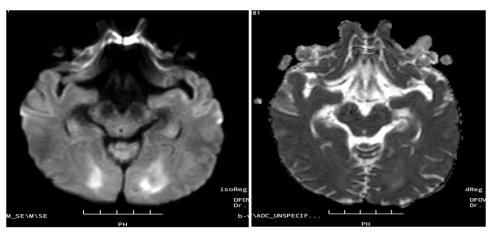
Brain MRI showing bright spots in both temporal lobes
